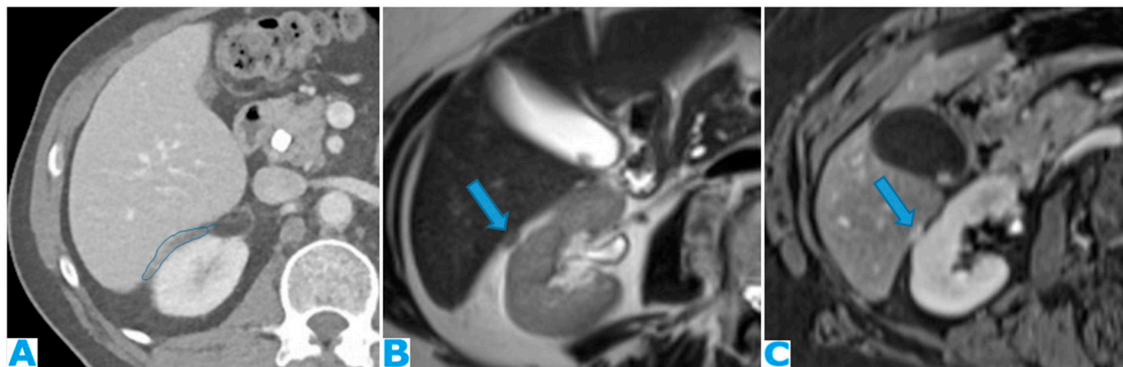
Axial CE-CT (A): PC from breast carcinoma: deposits within the subhepatic space as reticulation of its fatty content. Axial T2WI CE-CT (B), CE portal phase FST1WI (C): PC from colon carcinoma: nodular deposit within the subhepatic space (arrow).
